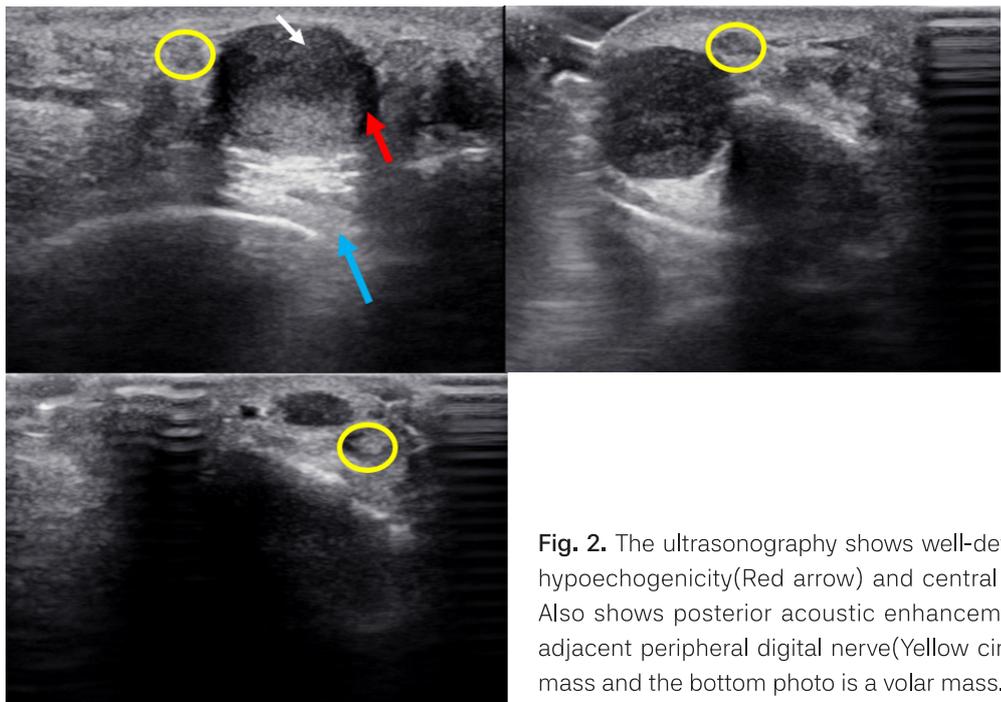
The ultrasonography shows well-defined schwannoma with peripheral hypoechoogenicity (Red arrow) and central hyperechogenicity (White arrow). Also shows posterior acoustic enhancement (Blue arrow) and contact with adjacent peripheral digital nerve (Yellow circle). Above two photos are dorsal mass and the bottom photo is a volar mass.
